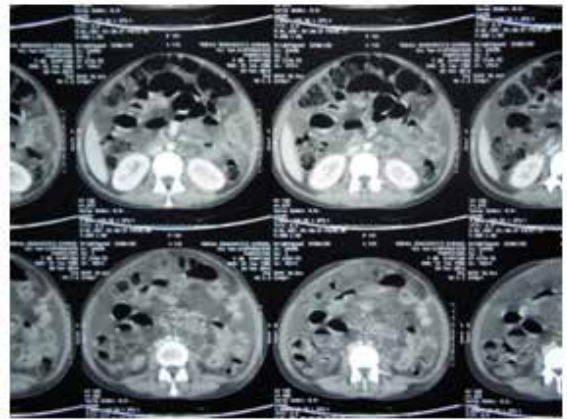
CT Abdomen showing bulky pancreas with prominent pancreatic duct suggestive of Acute Pancreatitis
